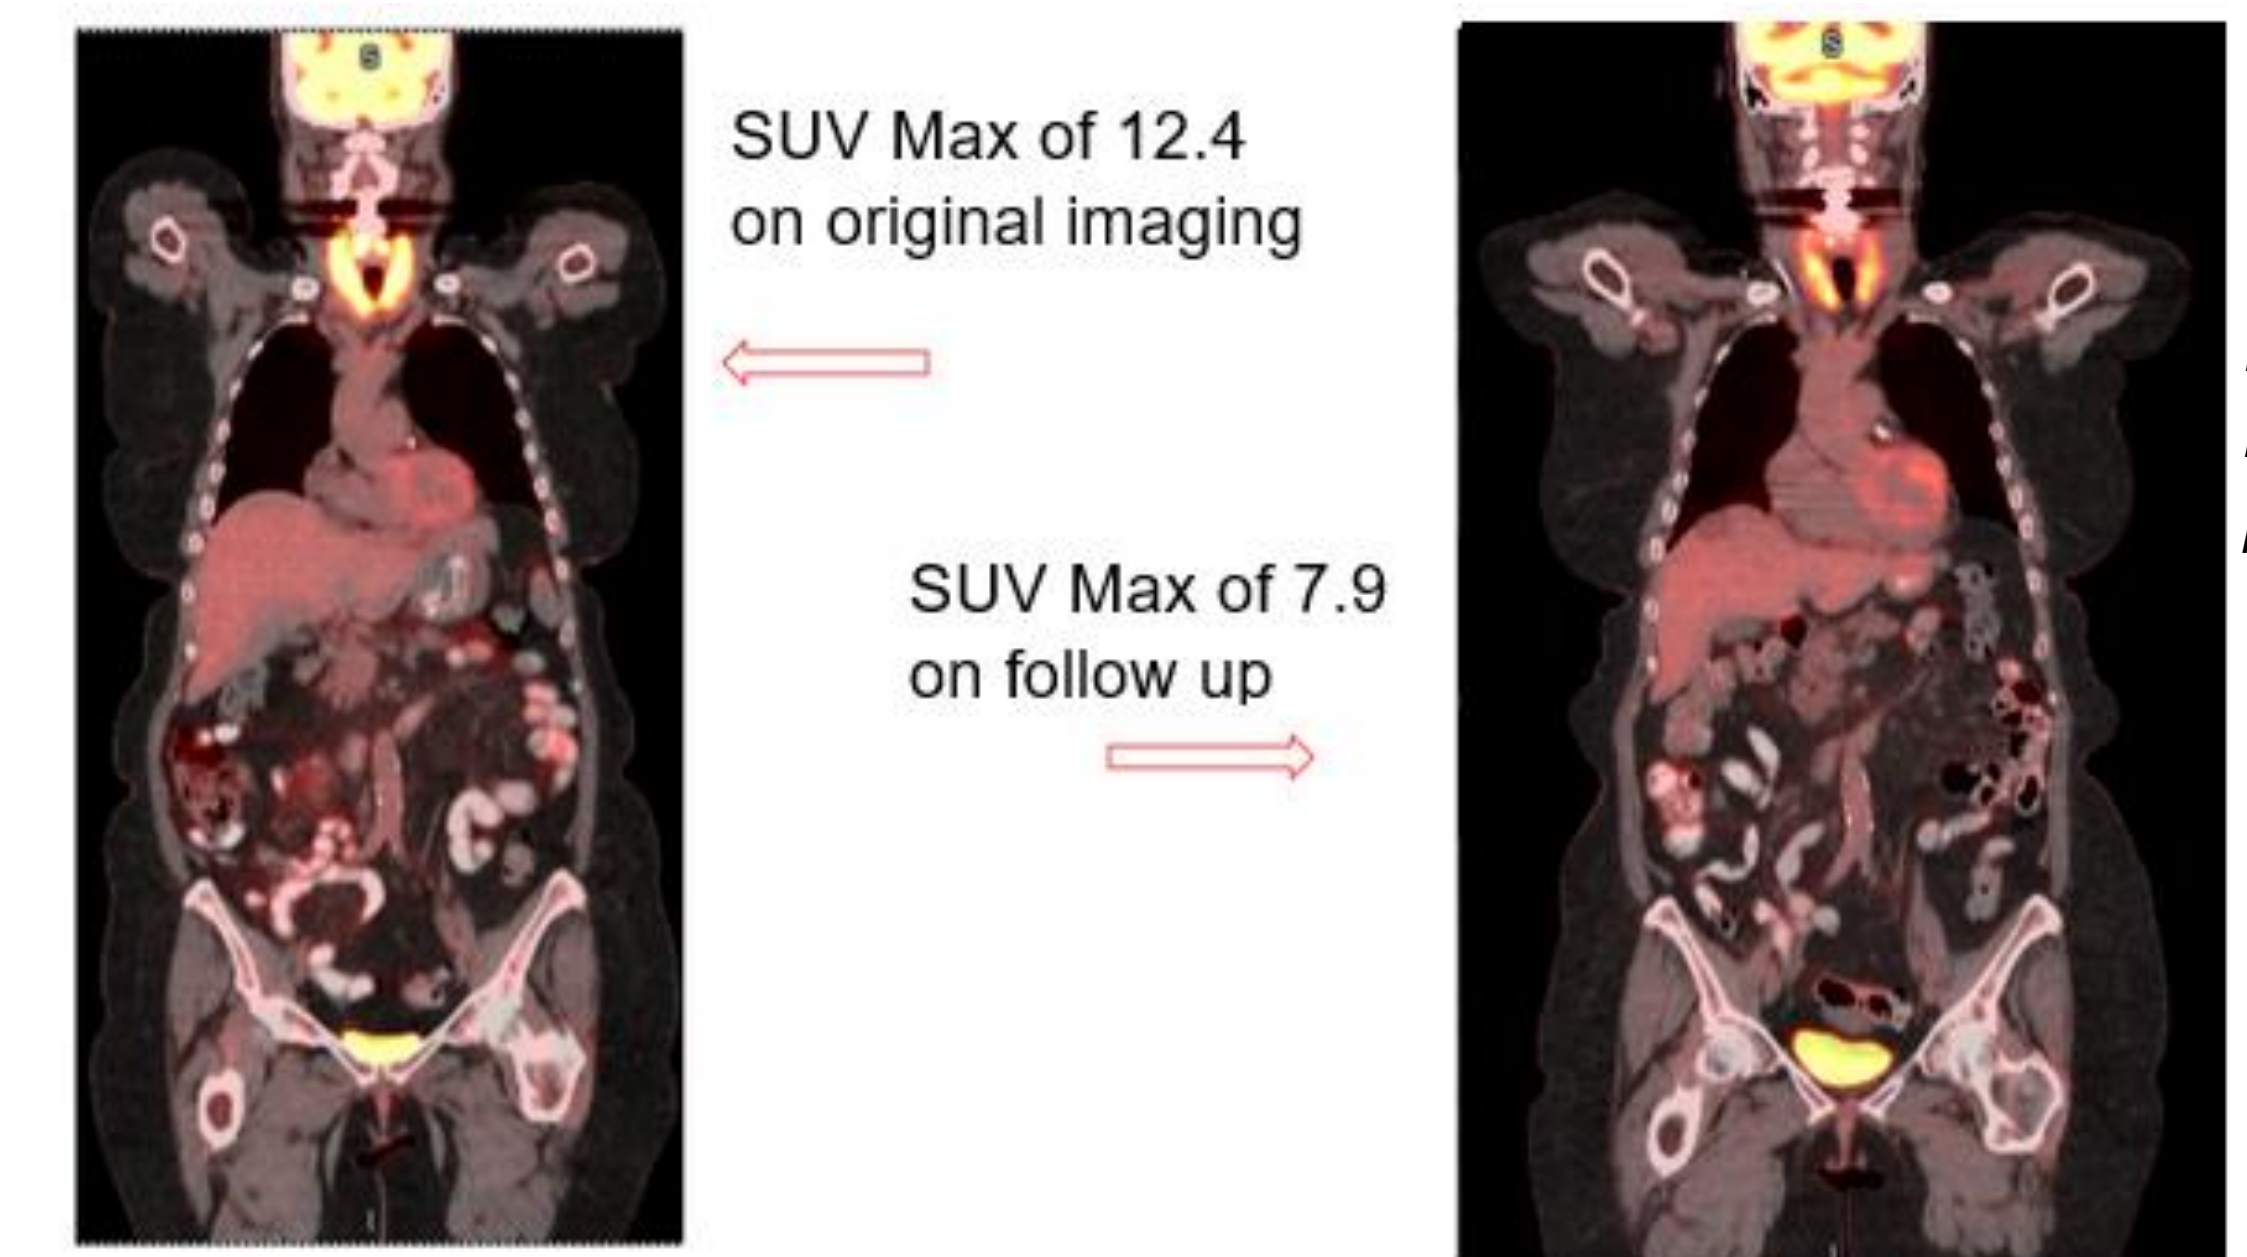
FDG-PET imaging prior to and post treatment
